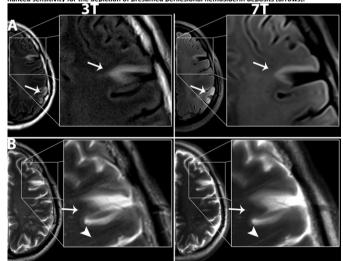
A) In FLAIR imaging, lesions identified at standard 3 T imaging were also readily visible at 7 T imaging (arrows).B) T2 imaging at 7 T allowed for the identification of lesions seen at 3 T (arrows) and provided higher spatial resolution, e.g. for the depiction of Virchow-Robin-spaces (arrowheads).
